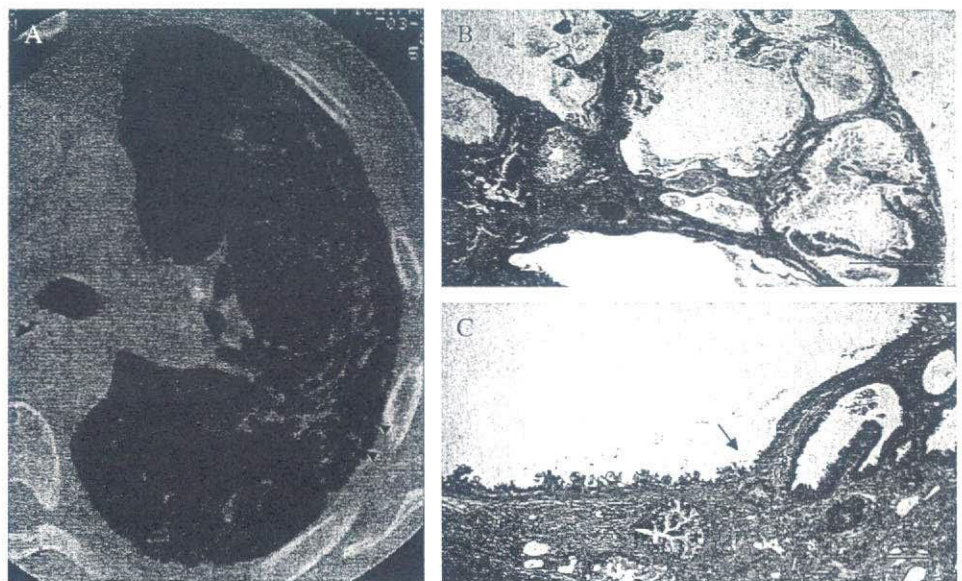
High-resolution computed tomography scan of lung adenocarcinoma associated with IPF shows honeycombing and extensive pleural thickening in the left hemithorax resembling malignant pleural mesothelioma.
